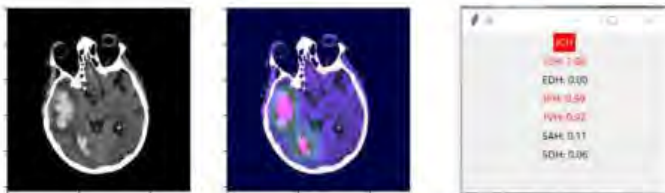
Grad-CAM highlights possible ICH locations. The raw CT image (left), the Grad-CAM map (middle), and the confidence score if ICH and prediction of subtypes (right). The redder the mapping, the stronger the prediction.
